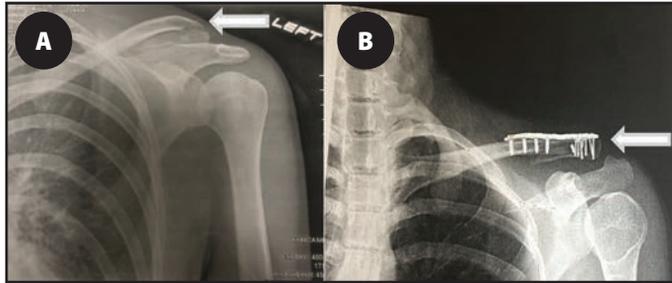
Radiographic imaging of left shoulder after patient fall. A, left distal clavicle fracture (arrow). B, Open reduction internal fixation of left clavicle fracture (arrow).
